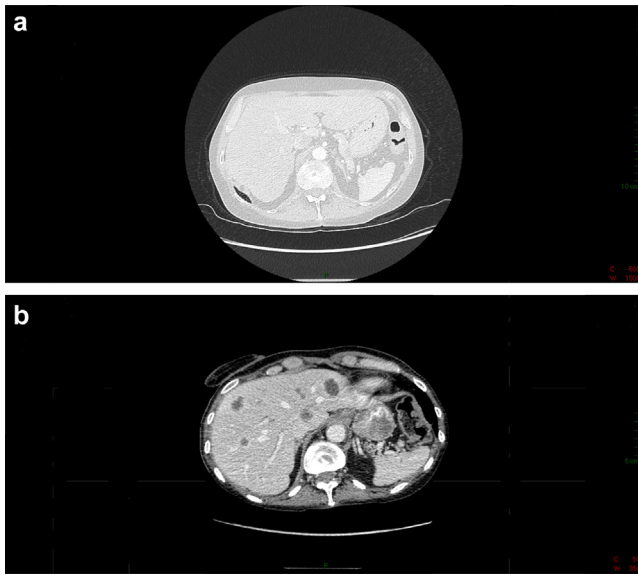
a: normal liver on CT scan; b: newly detected liver metastases on CT scan.
